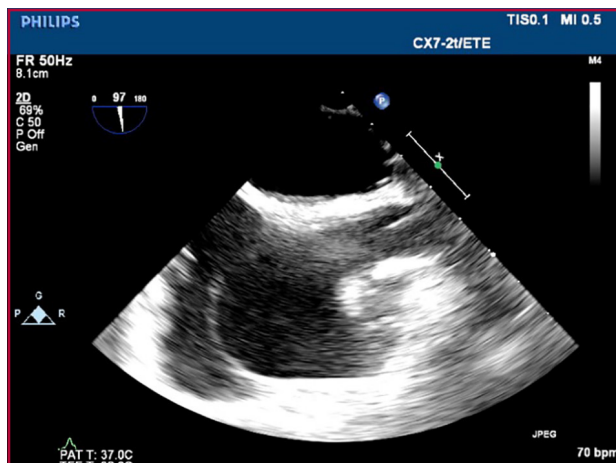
Transesophageal echocardiography bicaval plane. Post anticoagulation image of the pacemaker leads, without evidence of thrombus
